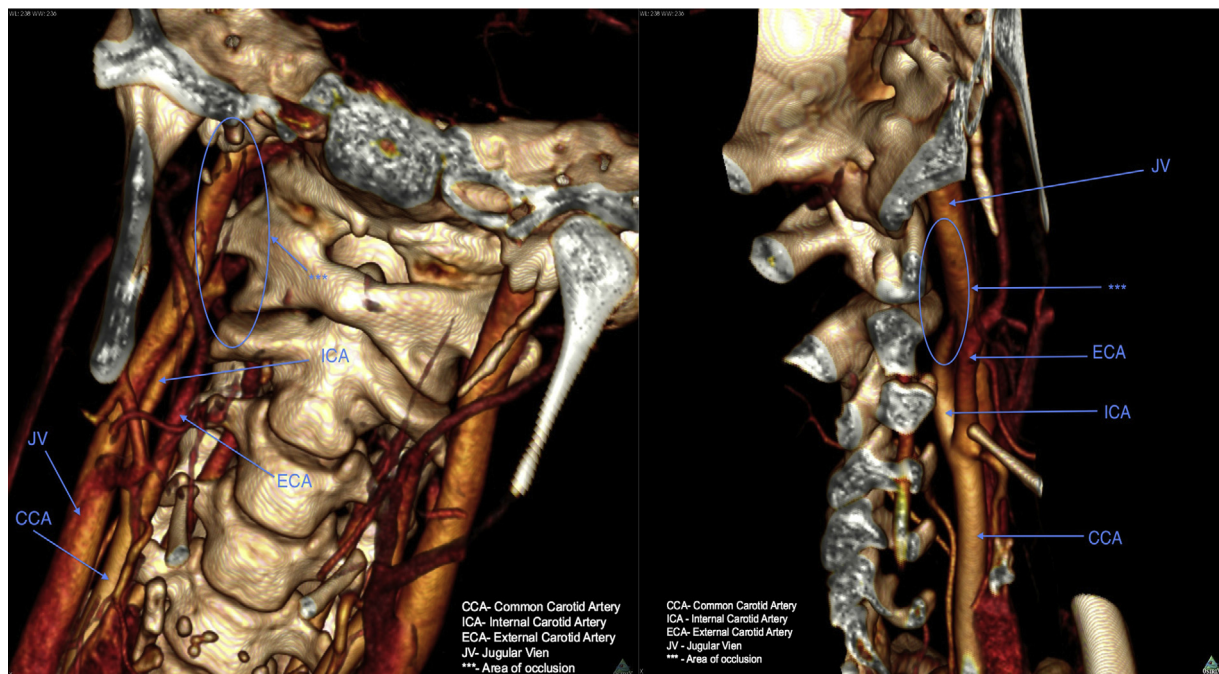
3D-CTA showing bilateral occlusion of the internal carotid artery in anterior and lateral view. CCA: common carotid artery, ICA: internal carotid artery, ECA: external carotid artery, JV: jugular vein, *: area of occlusion.
